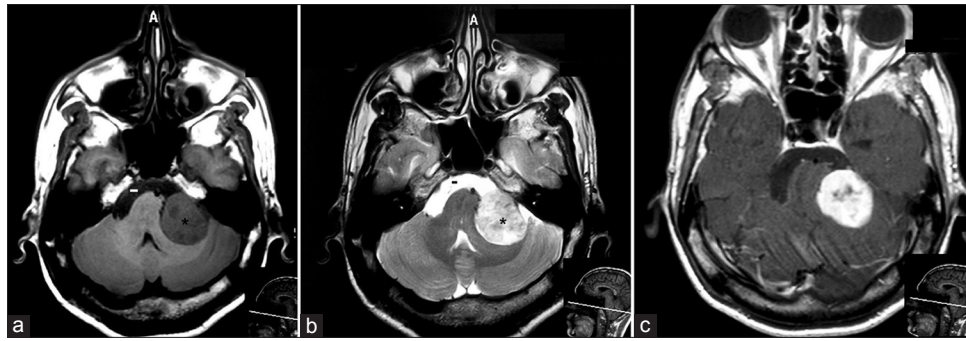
(a and b) T1 and T2 weighted MRI showing the schwannoma (*) and the epidermoid (-). (c) Contrast enhanced image where the schwannoma is enhancing
